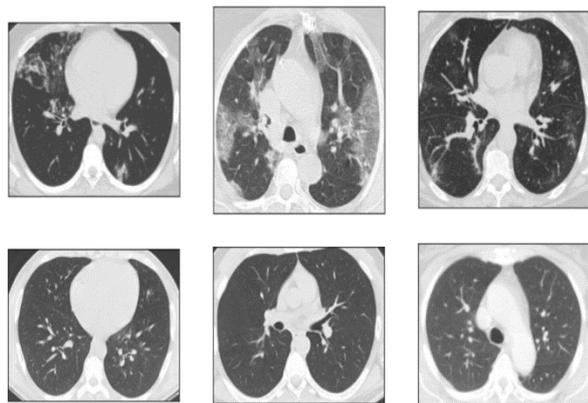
CT scans that are positive for COVID-19 (at the top of the image) and normal CT scans (at the bottom of the image) [22]
